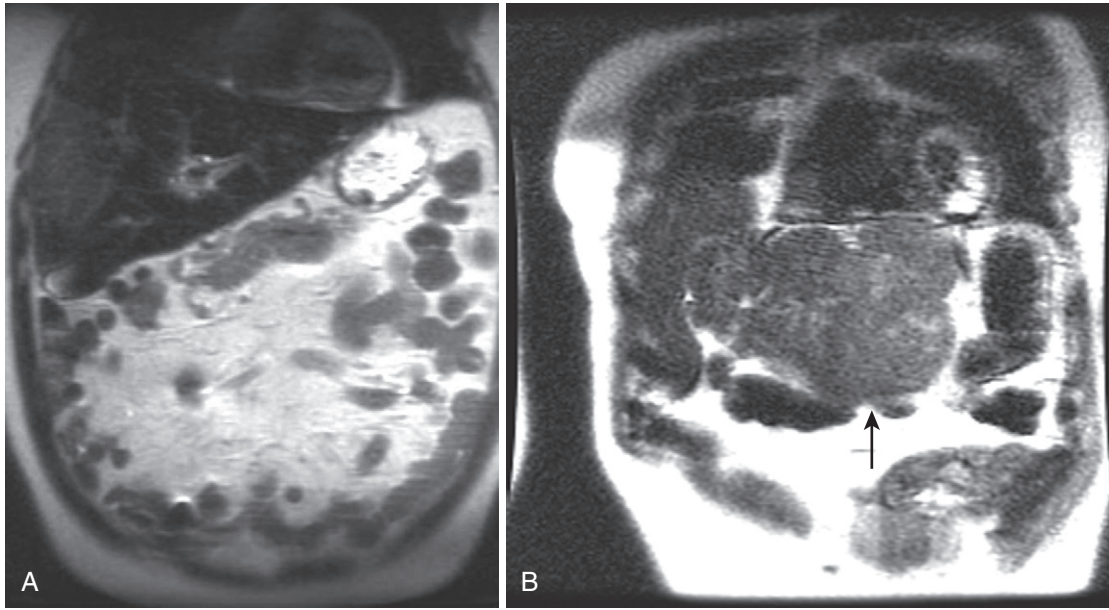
Assessing coil placement. A, Coronal localizing SSFSE T2-weighted image reveals maximal signal emanating from the lower abdomen, instead of the upper abdomen. B, Coronal localizing SSFSE T2-weighted image of a different patient reveals a mildly hyperintense exophytic lesion (*arrow*) arising from the lateral segment of the liver, which is well visualized because of optimal coil placement yielding superior signal over the region of interest.
